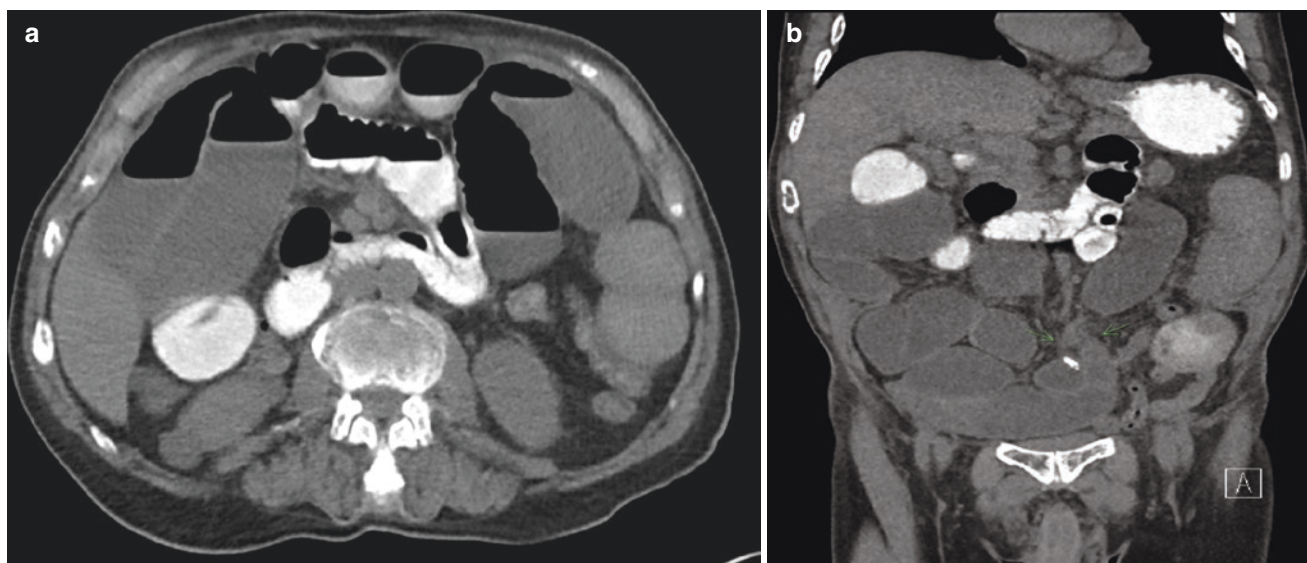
CT scan images of small bowel obstruction. (a) Representative axial section of CT scan of the abdomen and pelvis with PO and IV contrast showing dilated, fluid filled small bowel. (b)
